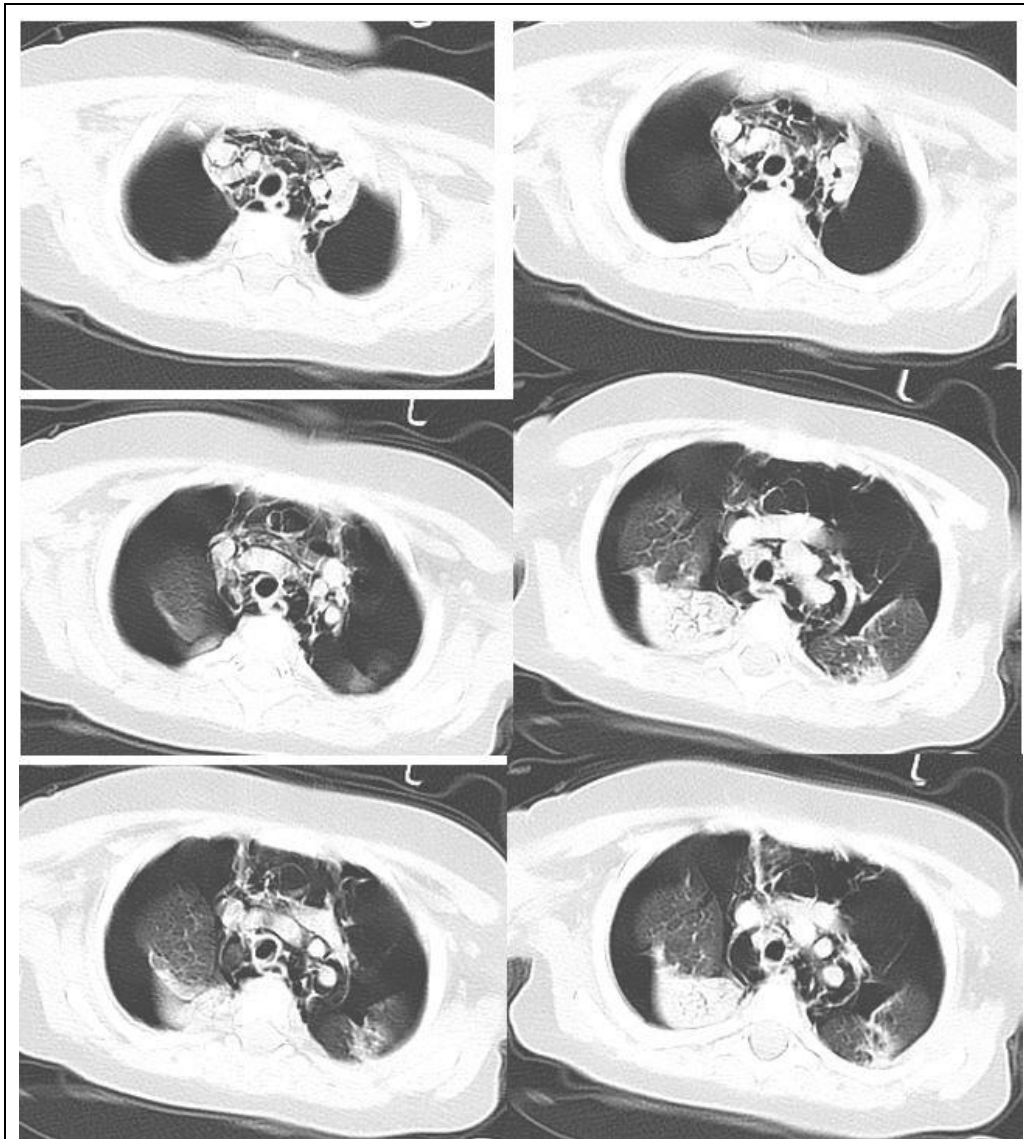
CT scan of chest showing pneumomediastinum, pneumopericardium and pneumothorax bilaterally.
